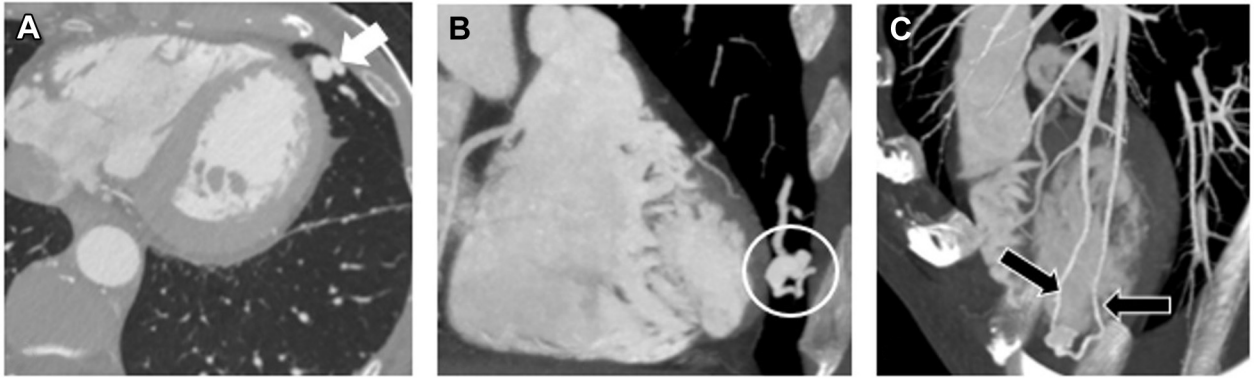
CT scan with contrast with a pulmonary arteriovenous malformation. A, B, Show the rounded, tortuous opacity within the lung periphery (white arrow, white circle). C, Shows the same rounded opacity with a feeding and draining vessel (black arrows).
